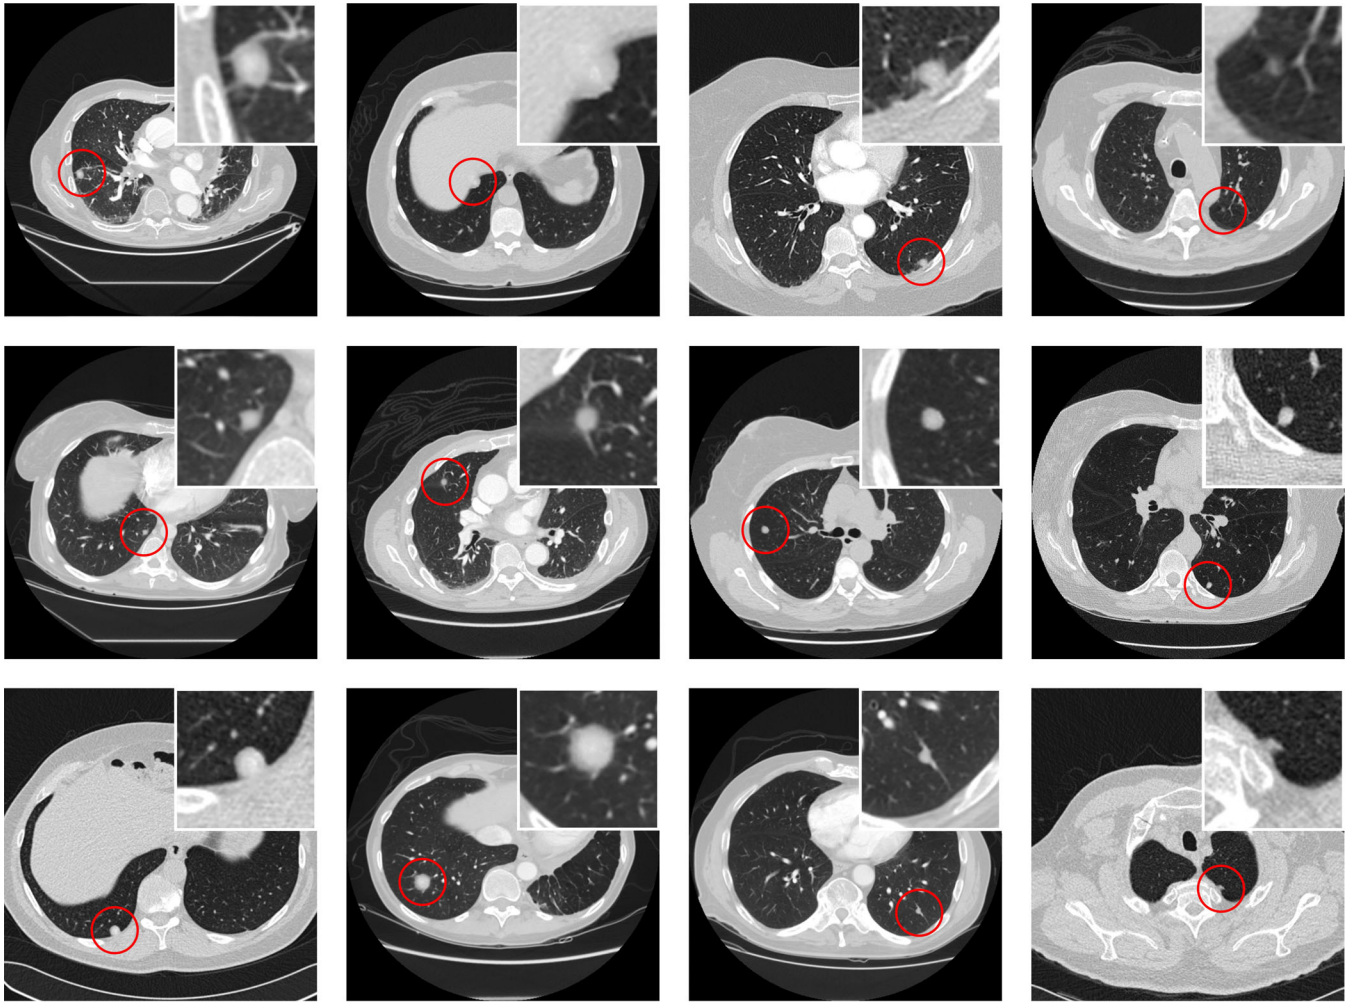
Examples of synthetic lung nodules in computed tomography images [Color figure can be viewed at wileyonlinelibrary.com]
